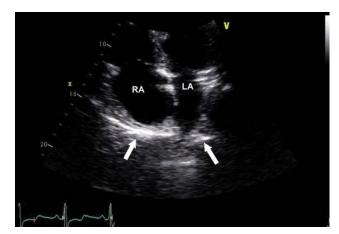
CP: apical four-chamber view in a patient with CP. *Arrows* point to pericardial calcification and thickening adjacent to the right and left atria, which result in tethering and constrictive physiology (Video A11).
